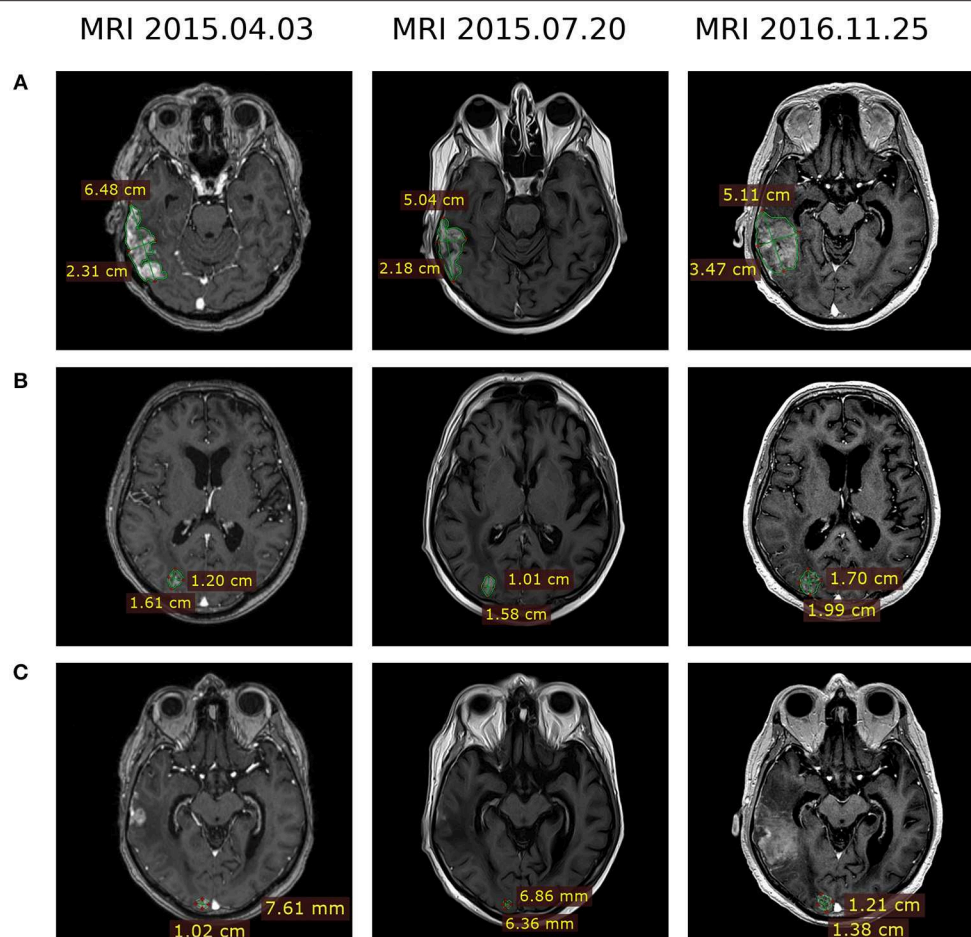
MRI evaluation of brain metastases dynamics at therapy lines 3 and 4 after development of the ceritinib resistance. Treatment regimens were pemetrexed + cisplatin (2015.04.03), topotecan followed by crizotinib (2015.07.20) and crizotinib + bevacizumab (2016.11.25). (A) Lesion 1, right temporoparietal region. (B) Lesion 2, right occipital lobe. (C) Lesion 3, right occipital lobe.
